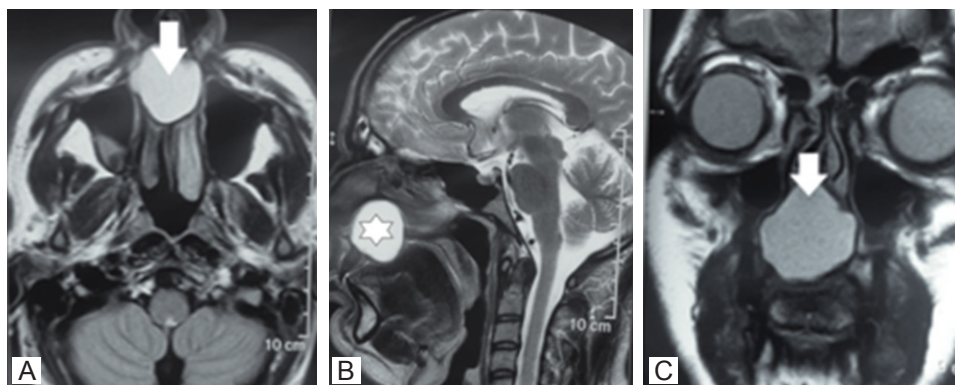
Plain magnetic resonance imaging face and neck region. (A) T2W image shows the well contained hyperintense cystic lesion on right side of the hard palate (vertical arrow); (B) T2W sagittal image shows hyperintense well demarcated lesion on the superior part of the hard palate (white star) on right side; (C) same lesion in T2WI coronal section with its superior extent (vertical arrow)
